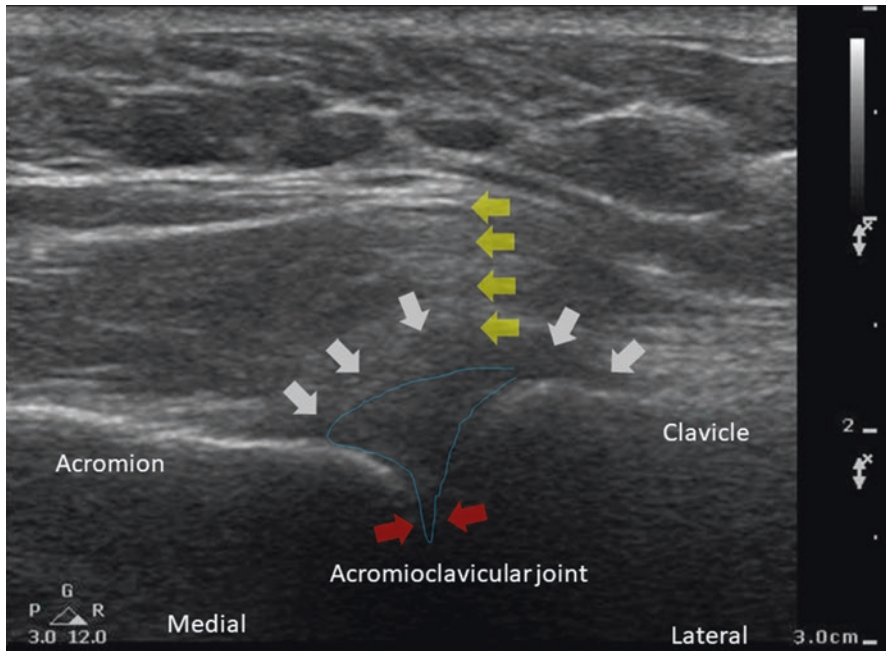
(a) Acromioclavicular joint ultrasound evaluation. (b) The clavicle has superior displacement in this image with a distended capsule outlined in yellow and mild joint fluid
